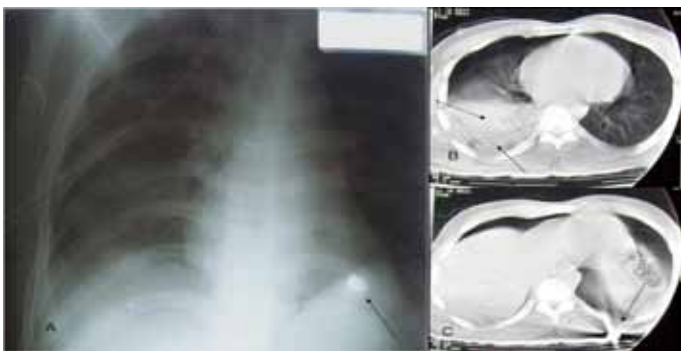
The bullet was at the left 8th costovertebral junction level on chest x-ray (A). In the computerized thorax tomography (CTT), the right lower lobe contusion and hemopneumothorax, the liver dome contusion with air densities and bullet were detected (B and C).
